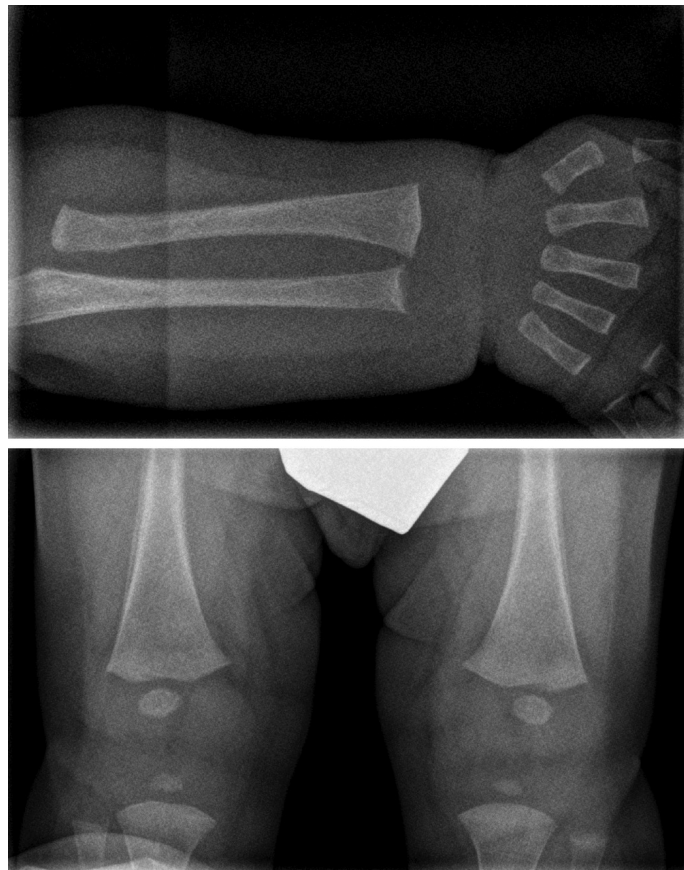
Radiographs at the time of the hypophosphatasia diagnosis
